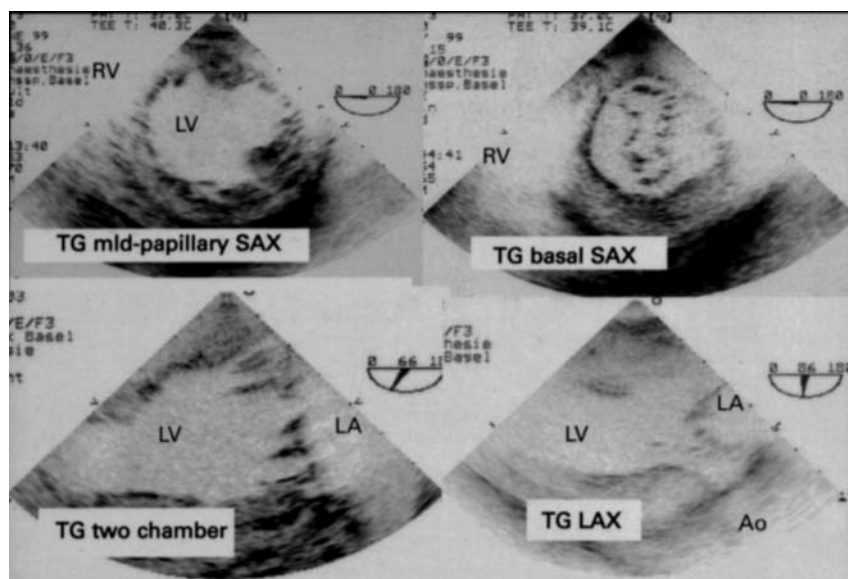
Comprehensive intraoperative transoesophageal echocardiography examination I: transgastric short-axis (TG SAX) and long-axis (TG LAX) views. Ao = aorta, LA = left atrium, LV = left ventricle, RV = right ventricle.
